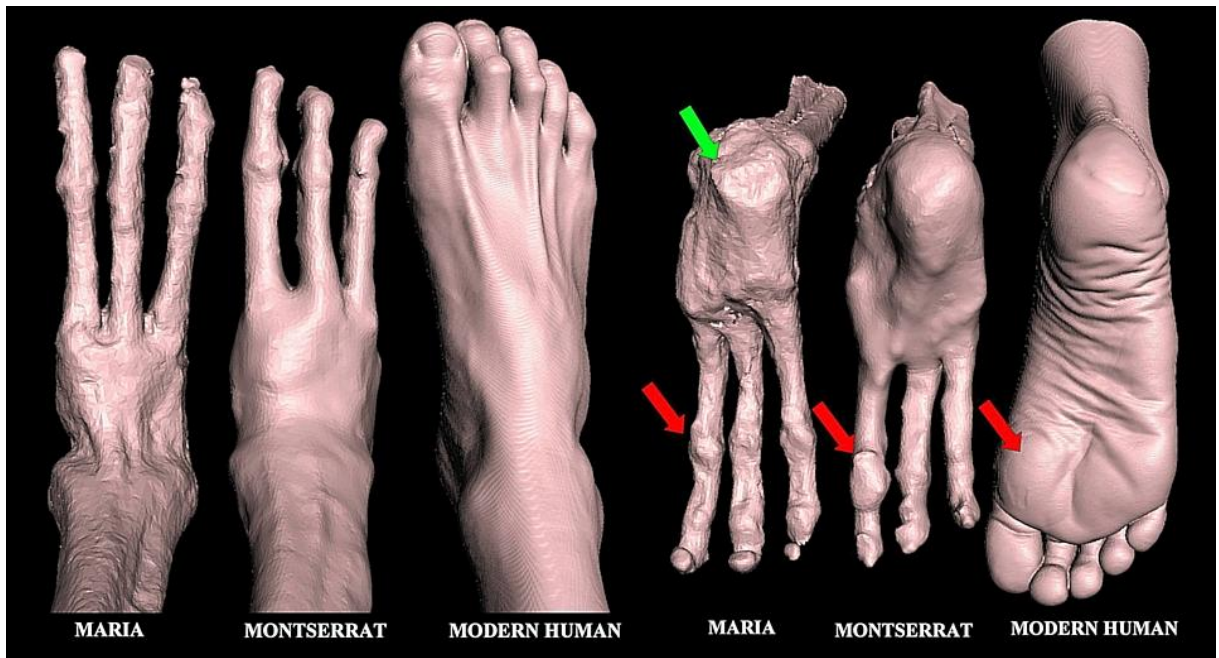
Comparison of 3D CT of right foot of Maria, Montserrat and modern human. Note the soft tissue pad over medial digits (*red arrows*) suggestive of weight-bearing points in addition to heel pads. Soft tissue in Maria appeared more atrophic than Montserrat. The heel of Maria appeared truncated and shortened (*green arrow*).
